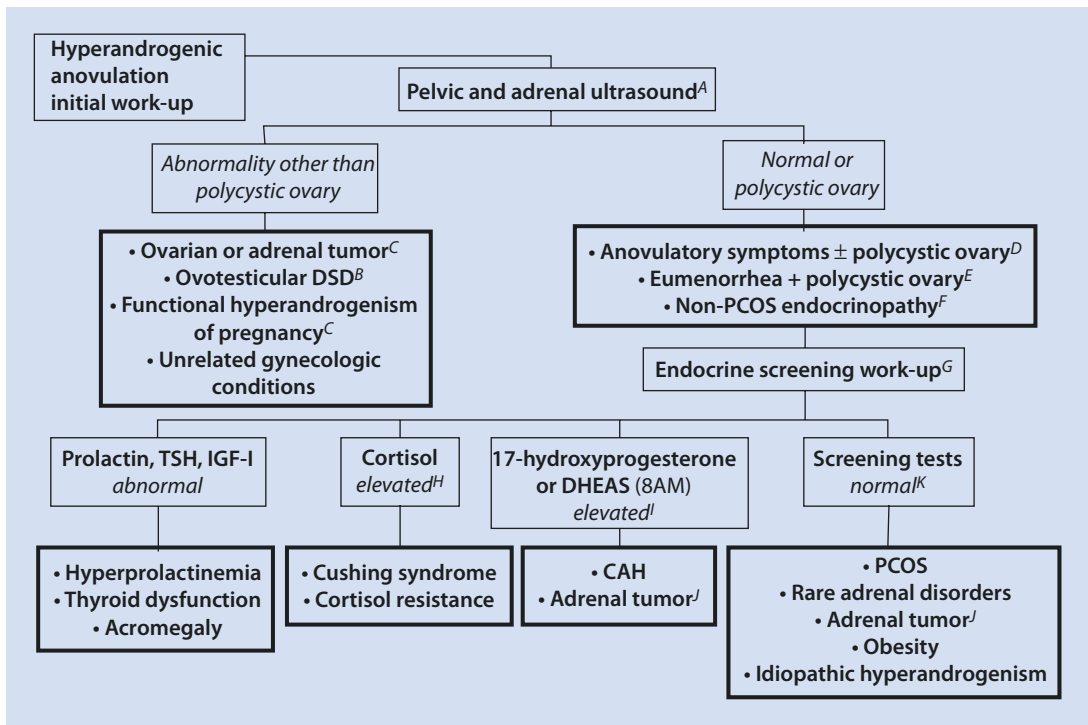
Initial workup of hyperandrogenism. This algorithm identifies the common causes of hyperandrogenism, which is most often due to PCOS (Modified from Rosenfield [78]). Footnotes: A. Ultrasonography is a study that detects polycystic ovaries and excludes ovarian pathology other than polycystic ovaries. It may be reserved for girls with rapid-onset symptoms, virilization, or lack of response to initial therapy. The abdominal ultrasound that is indicated for pelvic ultrasonographic imaging in virginal adolescents can also be used to screen for adrenal enlargement/mass. The current consensus criteria for polycystic ovary morphology in adults is an ovary with a volume > 10 cc and/or containing ≥12 follicles 2–9 mm diameter in the absence of a dominant follicle (≥10 mm diameter) or corpus luteum. One-third to half of normal adolescents meet these adult criteria. Until further research establishes definitive criteria, current evidence suggests that a mean ovarian volume > 12 cc (or single ovary >15 cc) be considered enlarged in adolescents; the normal range for follicle number in adolescents remains to be defined. Unless the ultrasound reveals an abnormality other than polycystic ovary morphology, further workup for hyperandrogenism is indicated. B. Ovotesticular DSD (disorder of sex development) was formerly termed true hermaphroditism. C. Virilization during pregnancy may be due to androgen hypersecretion by a luteoma or hyperreactio luteinalis. D. The presence of a polycystic ovary supports the diagnosis of PCOS in hyperandrogenic patients. The presence of a polycystic ovary is not necessary—nor does it suffice—for the diagnosis of PCOS in a patient with hyperandrogenic ovulation. E. In a eumenorrheic, symptomatically hyperandrogenic adolescent with normal menses, the presence of a polycystic ovary (which meets Rotterdam-AES diagnostic criteria in adults) is a risk factor for the diagnosis of PCOS. F. A polycystic ovary is not
